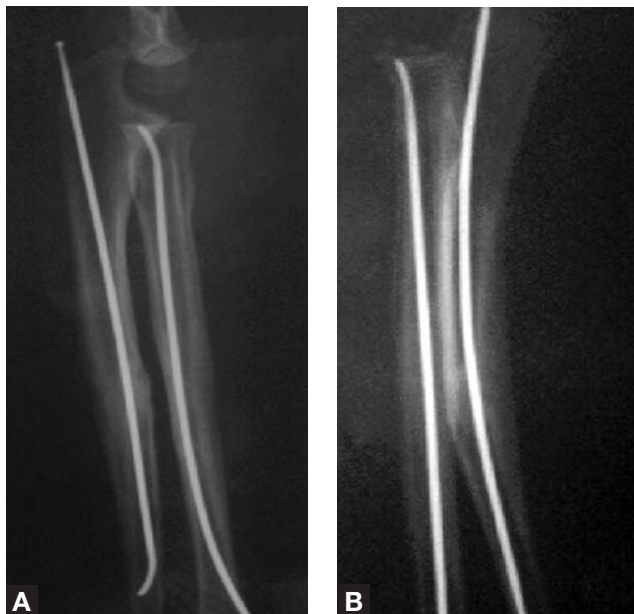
Anteroposterior (A) and lateral (B) radiographs at 5 months demonstrating union. Slight angulation of the radius is present; however, function is unaffected.
